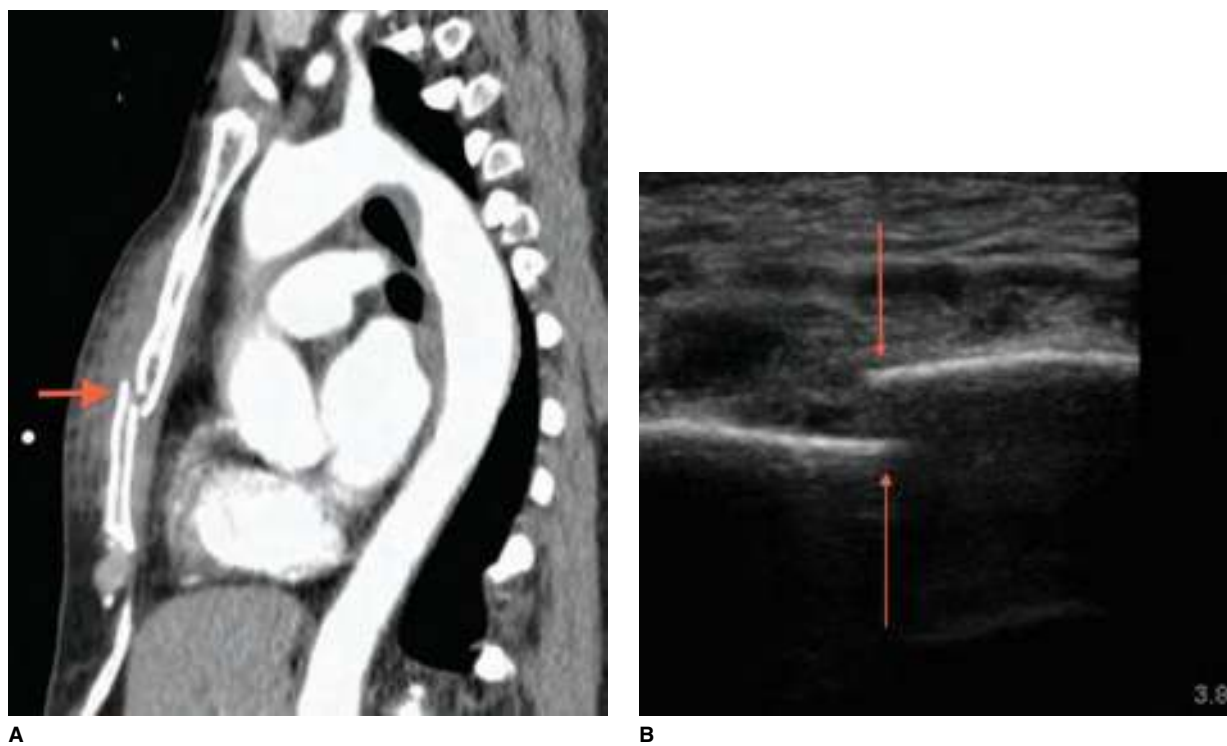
A sternal fracture. The *red arrows* identify the fracture. A. CT scan. B. US view. (Used with permission from reference 36.)
